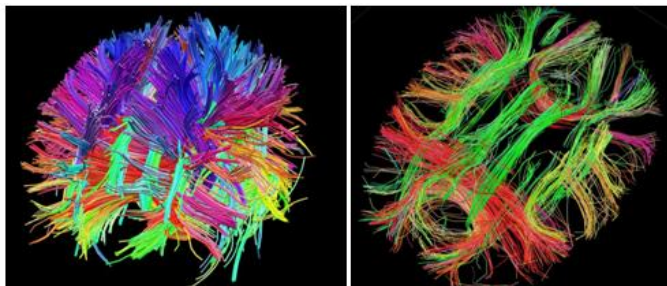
White matter fibres detected in vivo using Diffusion MRI. Images from the gallery of the Connectome Project (by Randy Buckner).
